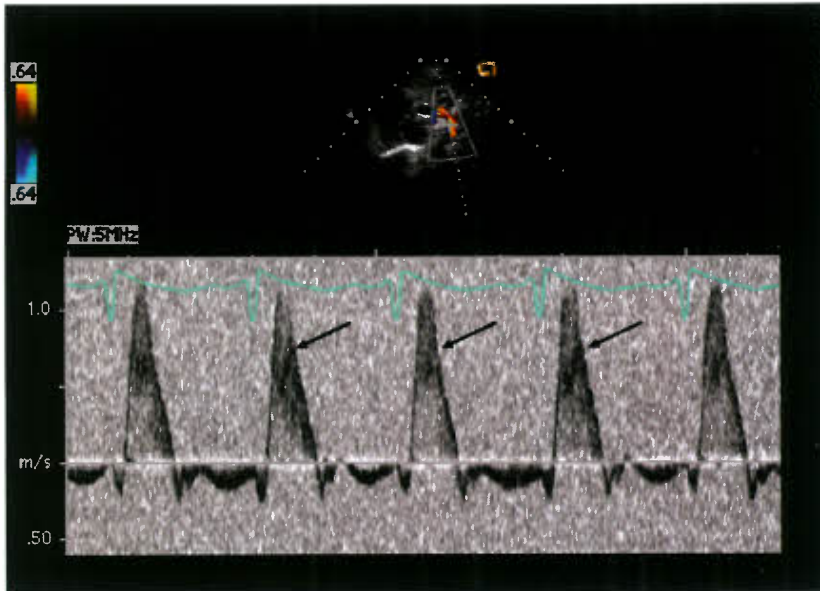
Pulsed Doppler examination from the suprasternal notch in a patient with HLHS. With the sample volume positioned in the transverse arch, retrograde systolic flow (arrows) from the patent ductus arteriosus into the aorta is identified, consistent with ductal-dependent systemic circulation.
